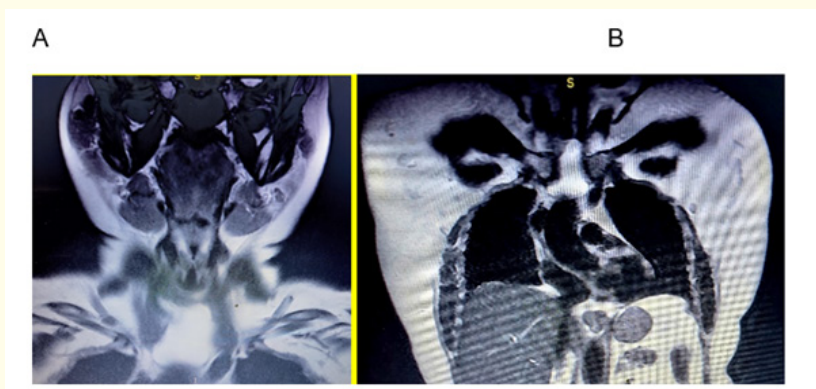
A-B- MRI of the neck and chest showing in coronal view, a cystic tumor located at the anterior cervicothoracic region extending from the lower edge of the left thyroid gland to the anterior mediastinum up to the aortic arch. There is no infiltration into vascular structures or adjacent organs.
